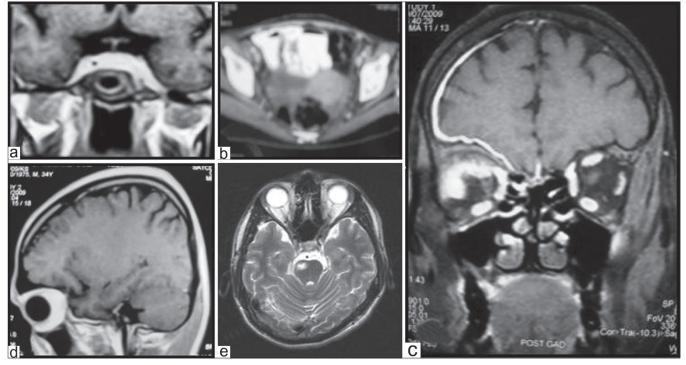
Magnetic resonance imaging (MRI) coronal gadolinium-enhanced T1WI showing thick meningeal enhancement of the dura mater in the parasellar region (a). Contrast-enhanced computerized tomography of the abdomen showing enhancing omental mass (b). MRI coronal gadolinium-enhanced T1WI showing thick meningeal enhancement of the right frontal dura mater and bulky superior and lateral rectii (c). MRI sagittal gadolinium-enhanced T1WI showing thick meningeal enhancement of the left temporal dura mater (d). MRI axial T2WI showing infarct in the right pons (e)
